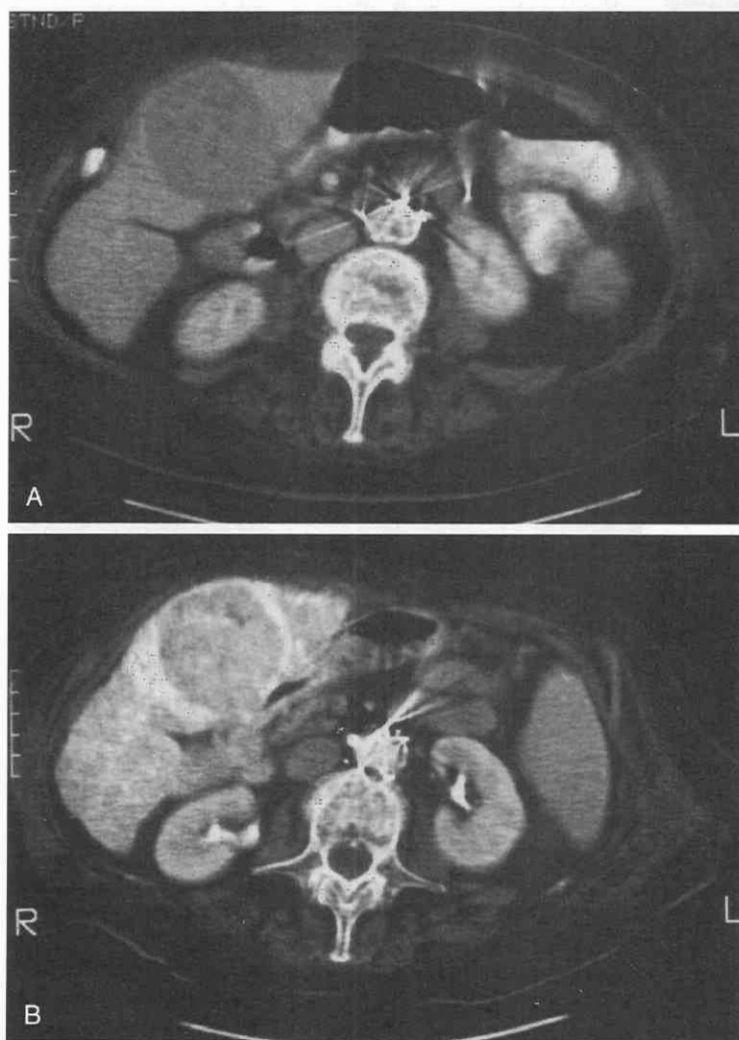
Encapsulated hepatocellular carcinoma in a cirrhotic liver. A, Contrast-enhanced CT scan demonstrates the well-defined, low-attenuation mass, which deforms the liver contour. B, CT scan performed during hepatic arterial injection of contrast more accurately demonstrates the enhancing rim.
